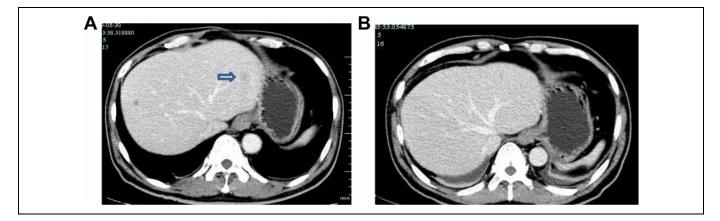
CT images liver metastases achieved complete remission after treatment. A: liver metastases before treatment; B: liver metastases after treatment.
